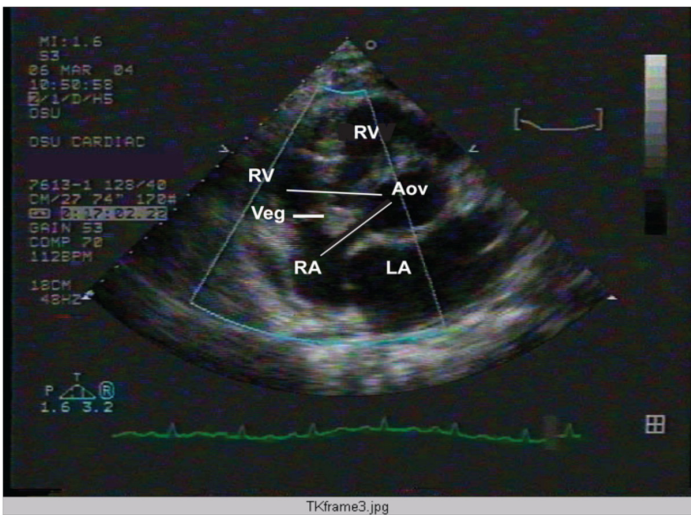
Echocardiographic parasternal short axis view showing a 2x2 cm vegetation, attached to the base of the septal leaflet of the tricuspid valve. [Veg: vegetation (thick line), RA: right atrium, RV: right ventricle, LA: left atrium, Aov: Aortic valve). Notice the two communications between the NCC of Aortic valve and right atrium as well as right ventricle (thin lines). Notice the vegetation attached to the base of the septal leaflet of the tricuspid valve, which is bordered with the dual rupture
